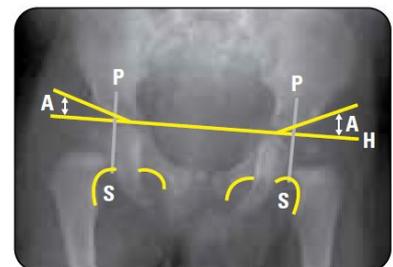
Pelvic x-ray and reference lines and angles for assessment of DDH
